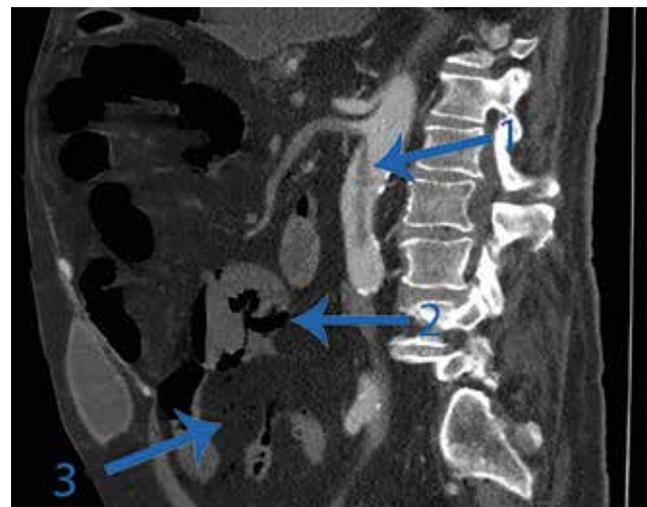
CT angiography of our patient showing: 1) a longitudinal thrombus from the superior to the inferior mesenteric artery, 2) pneumatosis intestinalis and 3) gas in the mesenteric veins
